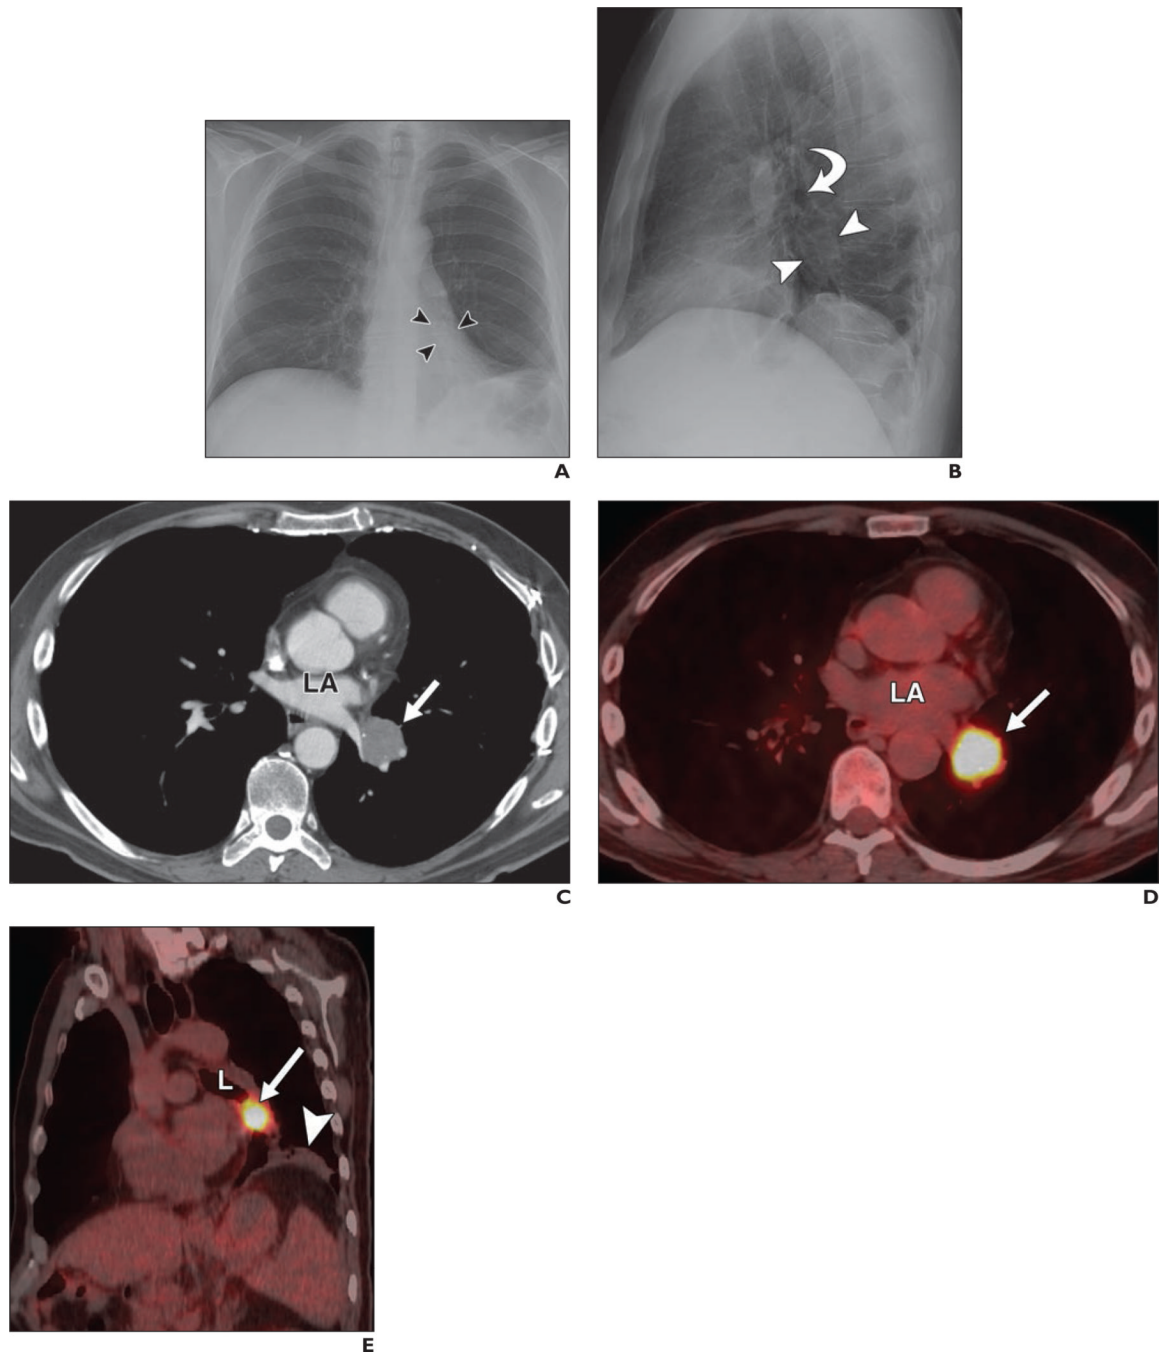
55-year-old man with adenoid cystic carcinoma of left lower lobe bronchus incidentally discovered on routine chest radiography
